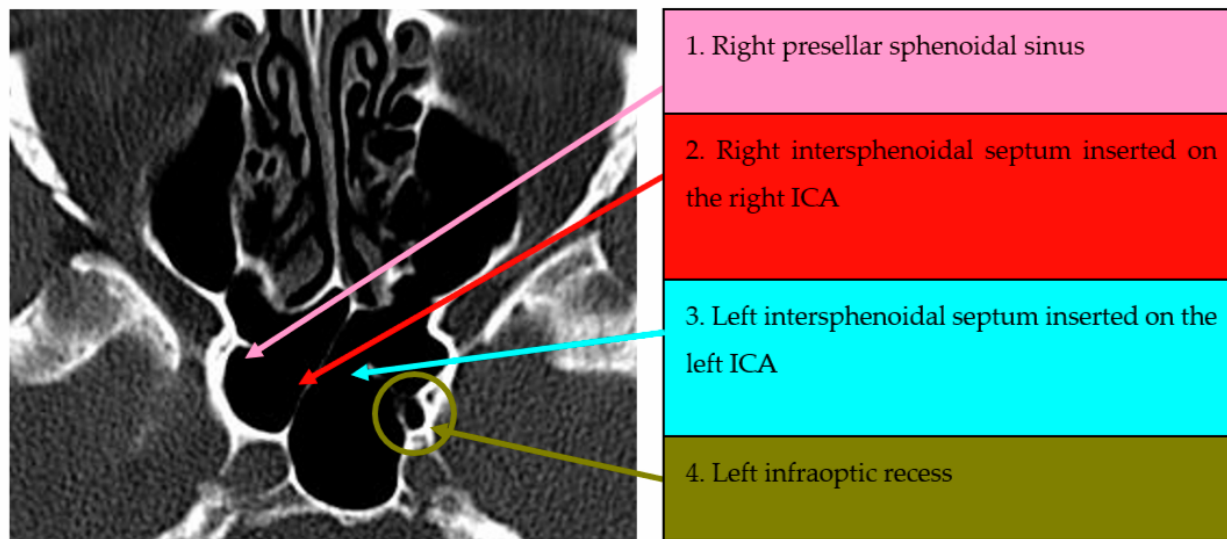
Axial CT section of paranasal sinuses. Right intersphenoidal septum. Incomplete left intrasphenoidal septum, posteriorly inserted on the ICA.
